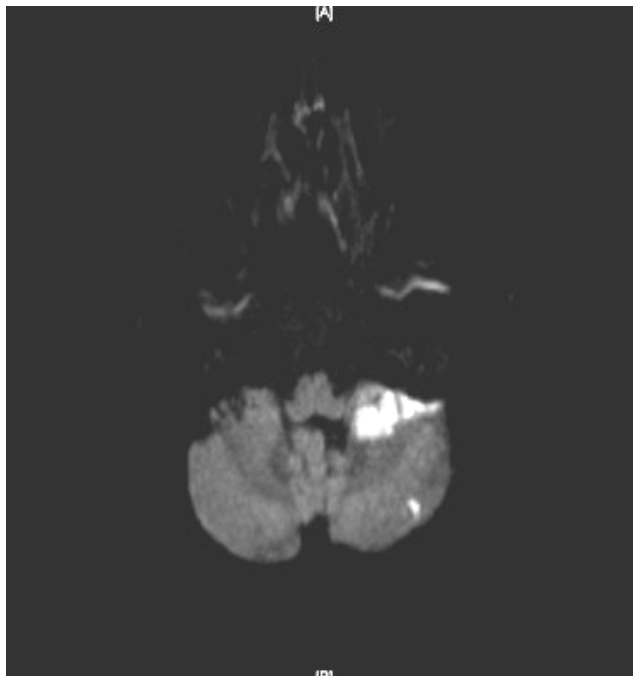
Diffusion Weighted Imaging of Brain MRI Showed High Signal Intensity Over Left Side Upper and Lateral Portion of Cerebellar Region Suggestive of Left Side AICA Territory Infarct (Black Arrows).
